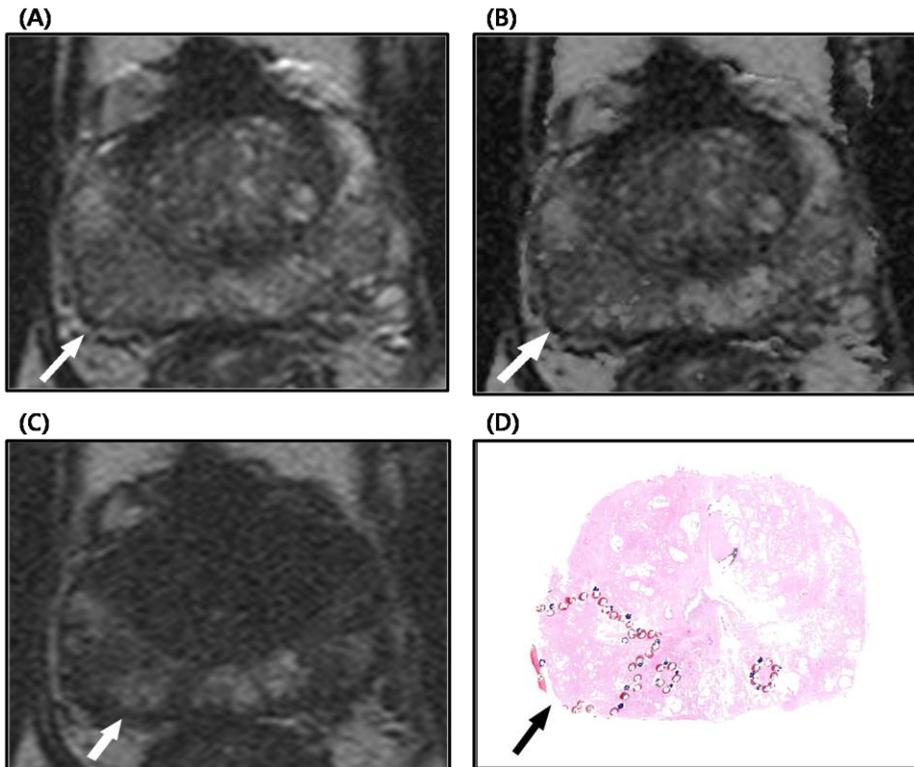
Good conspicuity on T1/T2 registration MR imaging in 67-year-old man with prostate cancer
